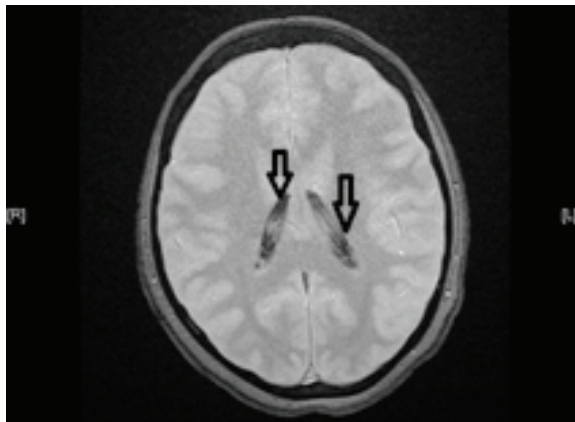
MRI picture, GRE image showing lateral ventricles with hypointensity
